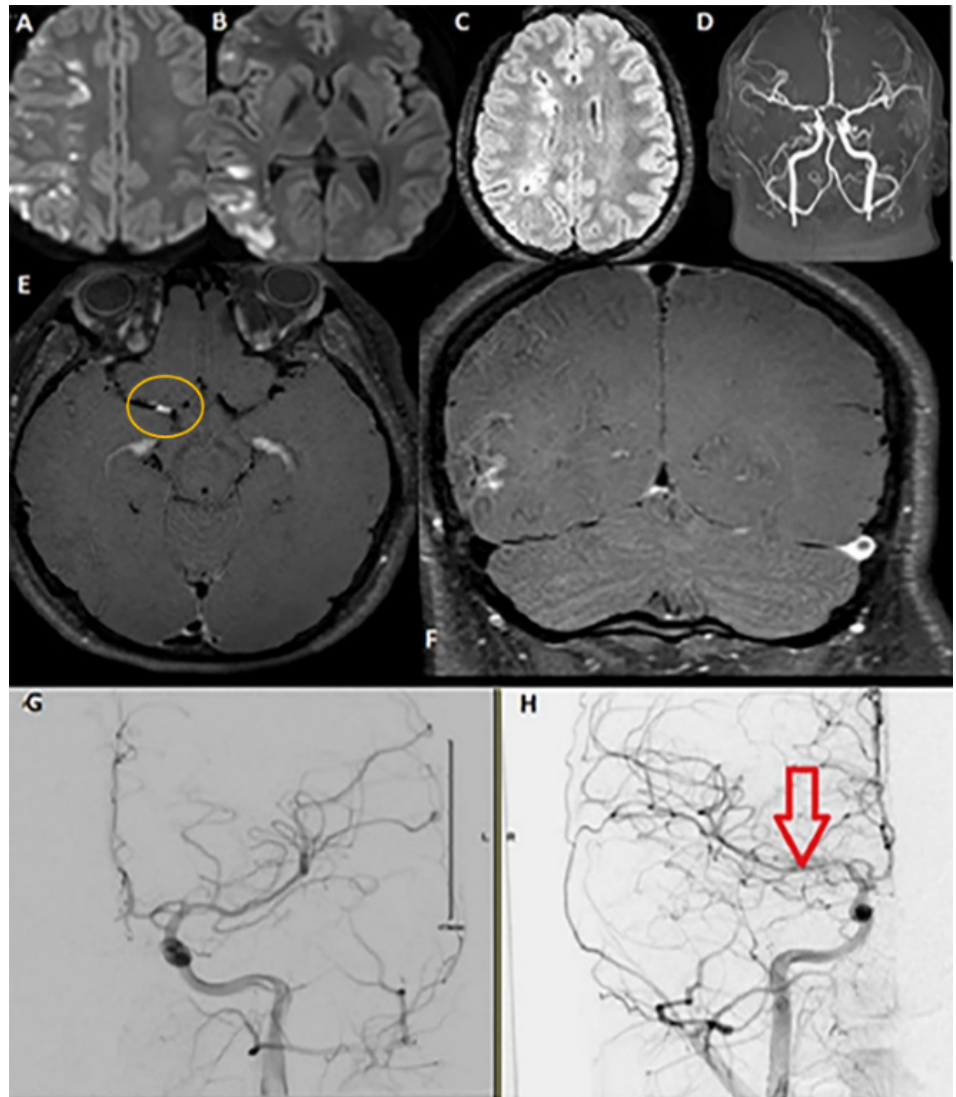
[A, B] Diffusion weighted imaging (DWI) and T2 FLAIR. [C] showed right hemispheric embolic watershed acute-subacute infarcts. [D] Magnetic resonance angiogram (MRA) showed focal right paraclinoid internal carotid artery (ICA), right proximal middle proximal cerebral artery (MCA) stenosis. There is moderate irregularity and stenosis in the right anterior cerebral artery (ACA) in both A1 and A2 segments. [E, F] Magnetic Resonance Angiogram (MRA) with vessel wall imaging showed a right proximal middle cerebral artery eccentric contrast enhancement (Orange Circle). [G, H] Cerebral Angiogram [red arrow] showed focal right MCA stenosis without limiting flow.
